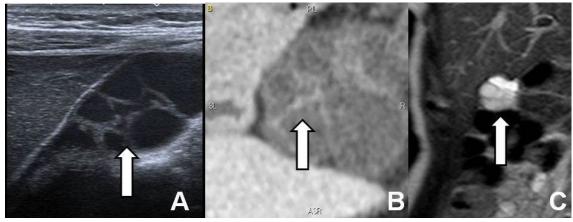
Transabdominal sonography showed complete and incomplete longutinal a transverse septas in the gallbladder body.
